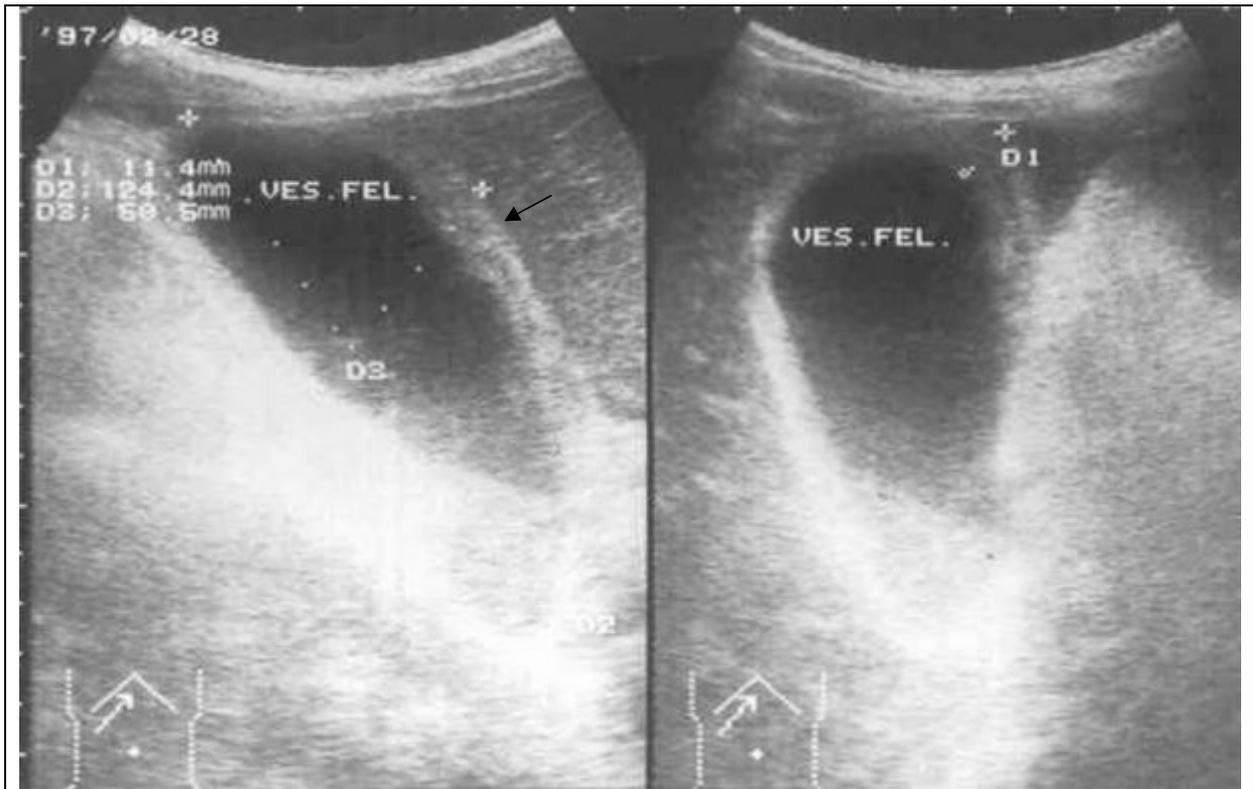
Ultrasound indications: uneven thickening of wall of gallbladder (more than 3 mm) with its inhomogeneity (arrow). Edema and infiltration of tissue around gallbladder. CT is indicated at complications, or when ultrasound is insufficiently informative.
